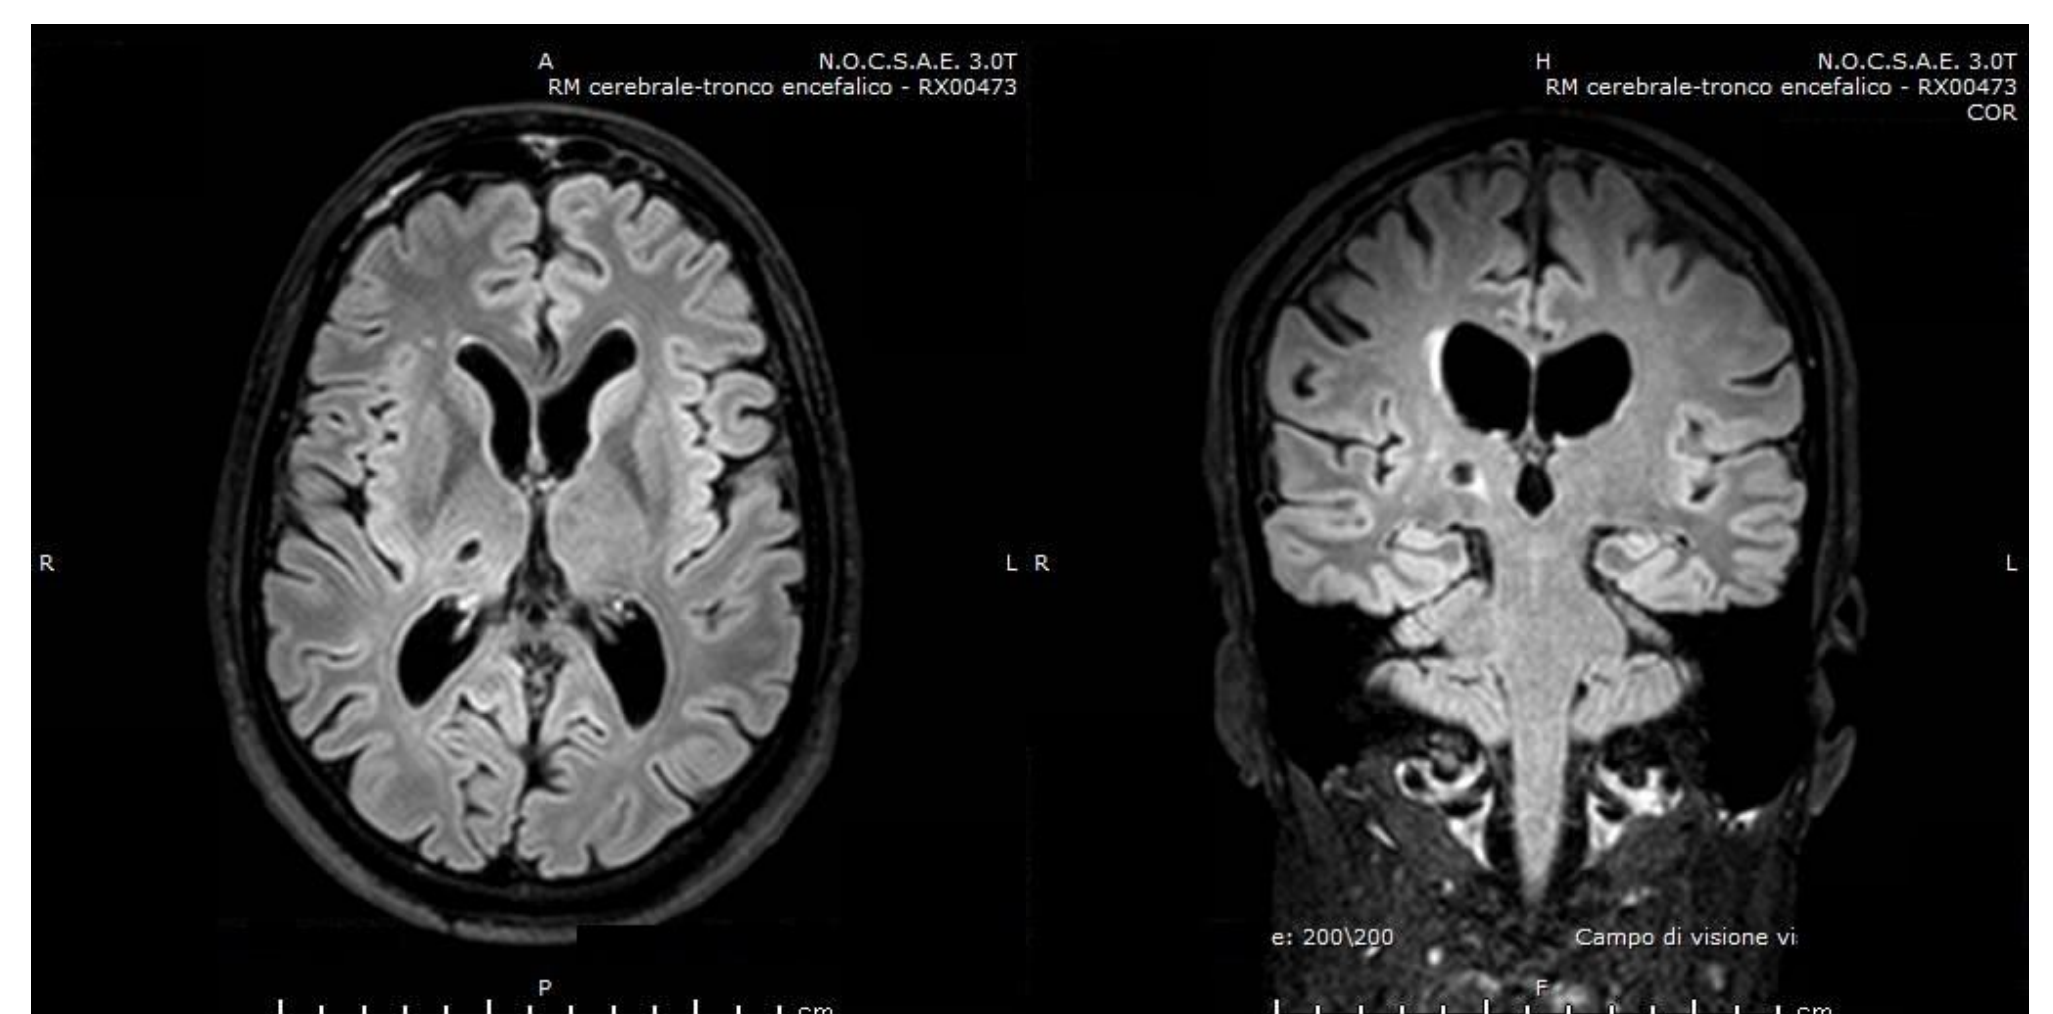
Brain MRI (FLAIR): chronic right thalamic infarction involving the ventral posterior nuclei
